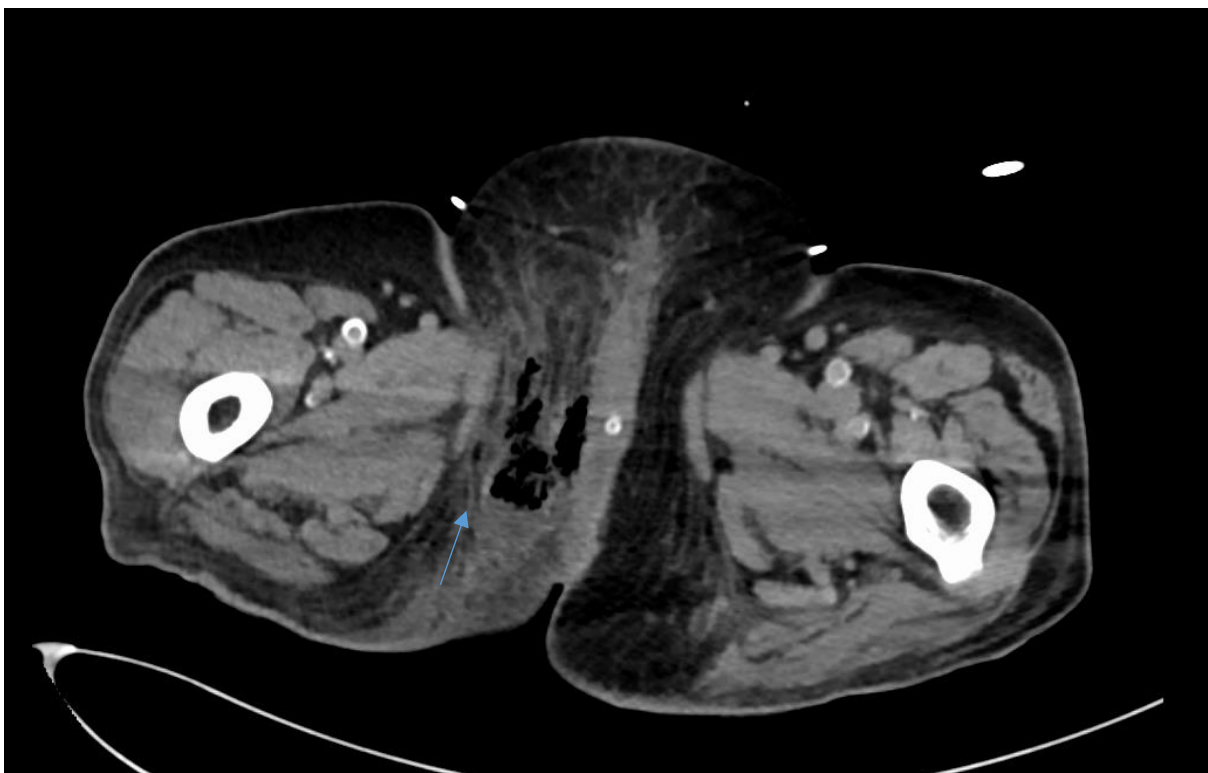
CT scan showing extensive subcutaneous emphysema within the perineum.
